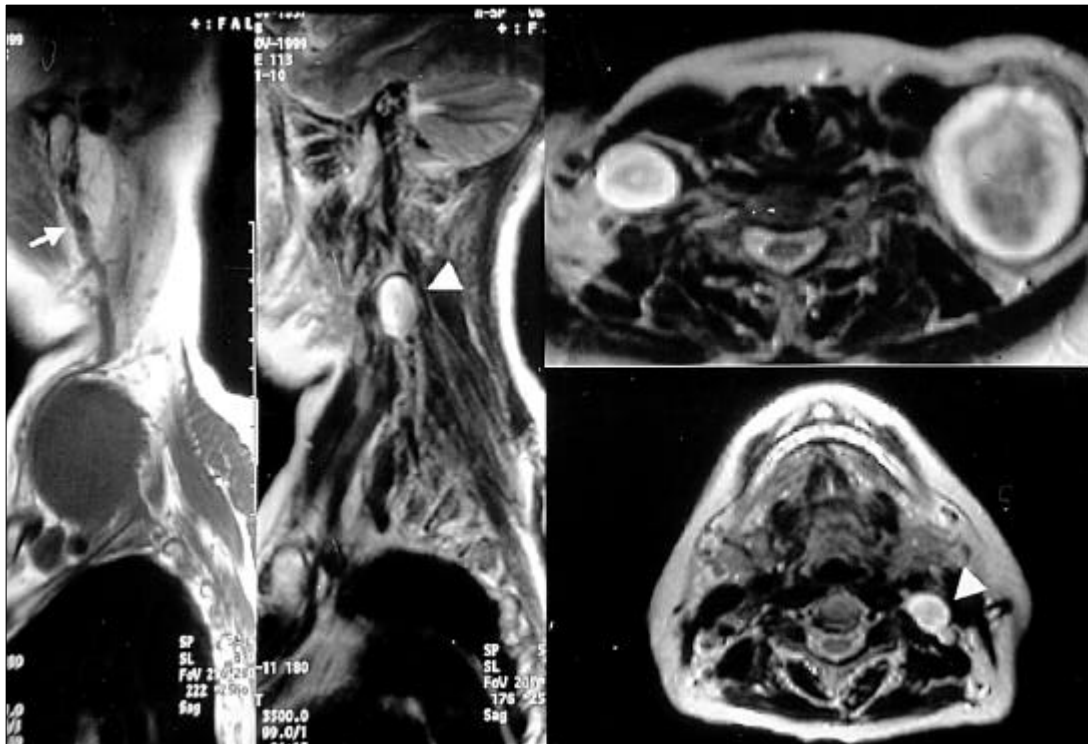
Magnetic resonance imaging of the brachial plexus showing two enhancing masses at the bilateral brachial plexus and one small mass (arrowhead) located behind the jugular vein. The external jugular vein (arrow) is dilated due to compression of the tumor.
